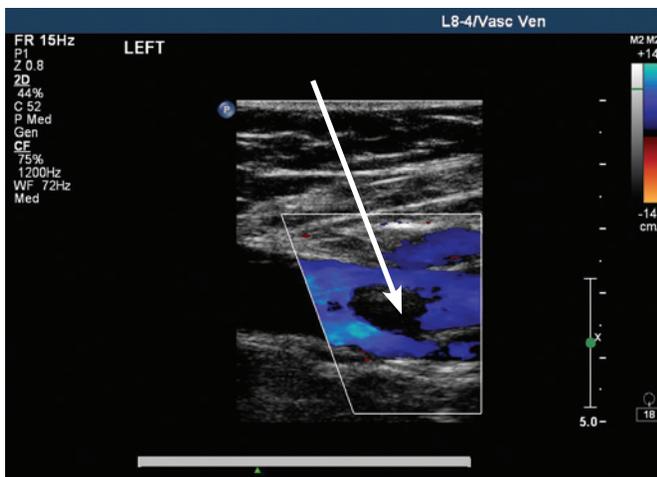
Duplex image of acute common femoral vein thrombosis outline by color Doppler. Arrow points to thrombus.
